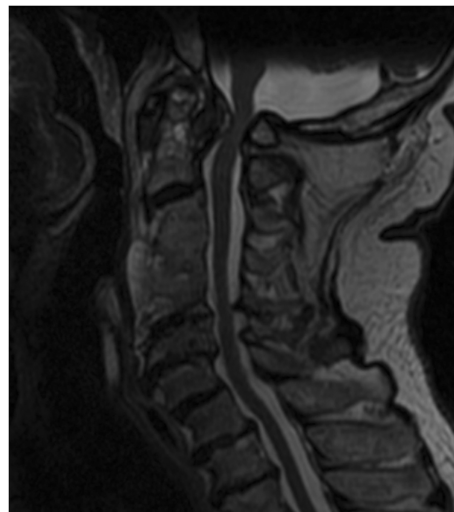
MR imaging findings in a 73-year-old man with DISH. T2-weighted sagittal MR image shows pannus formation at the craniocervical level and C1–C2 articulation causing severe compression of the medulla oblongata and spinal cord. The hyperintensity within the cord indicates myelopathy. Note the vertebral body fusion at C3–C4–C5 levels.
